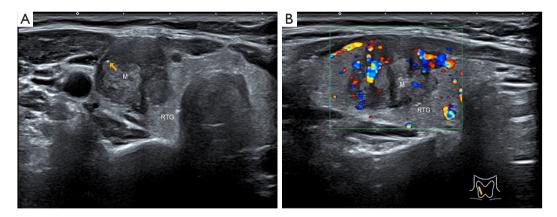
A 47-year-old woman with PTC. Preoperative ultrasound of the thyroid nodule in the right lobe showed the following features: irregular margin, capsule contact, micro-calcification (yellow arrow). No suspicious lymph nodes were found in the bilateral neck by ultrasound. The risk of CLNM based on nomogram for this patient was about 80%. Surgical pathology confirming cervical lymph node metastasis from PTC. PTC, papillary thyroid carcinoma; CLNM, central lymph node metastasis; M, mass; RTG, right lobe of thyroid gland.
